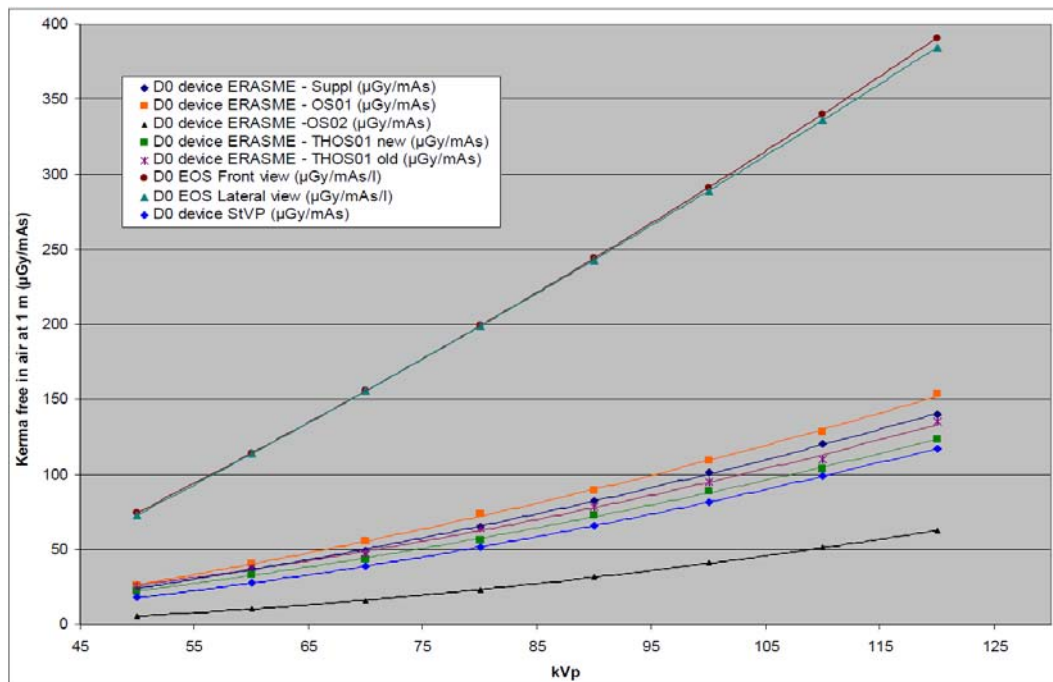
Dose rate measurements for EOS prototype and conventional geometry x-ray equipment, assessed along the EOS clinical trials .
